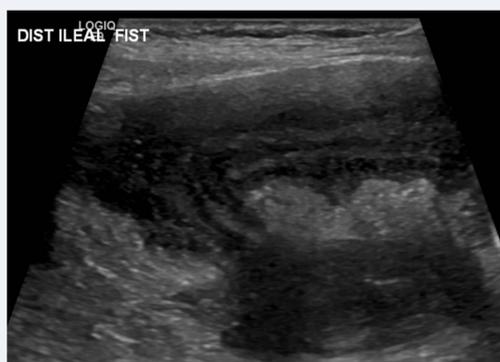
Ultrasound image demonstrating fistula between distal ileum and adjacent small bowel loop.
